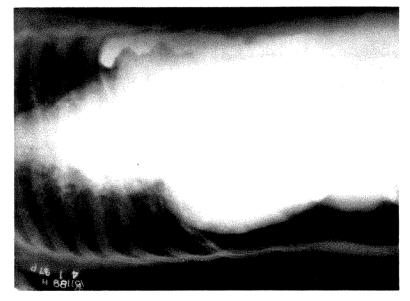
Film of the abdomen taken with the patient lying on the left sade and the roentgen beam directed in a horizontal plane. The normal outlines of the lateral margin of the liver and kidney are clearly seen. The shadow of the right diaphragm is not well reproduced. The position of the descending colon is indicated by a small barium residue in it.
